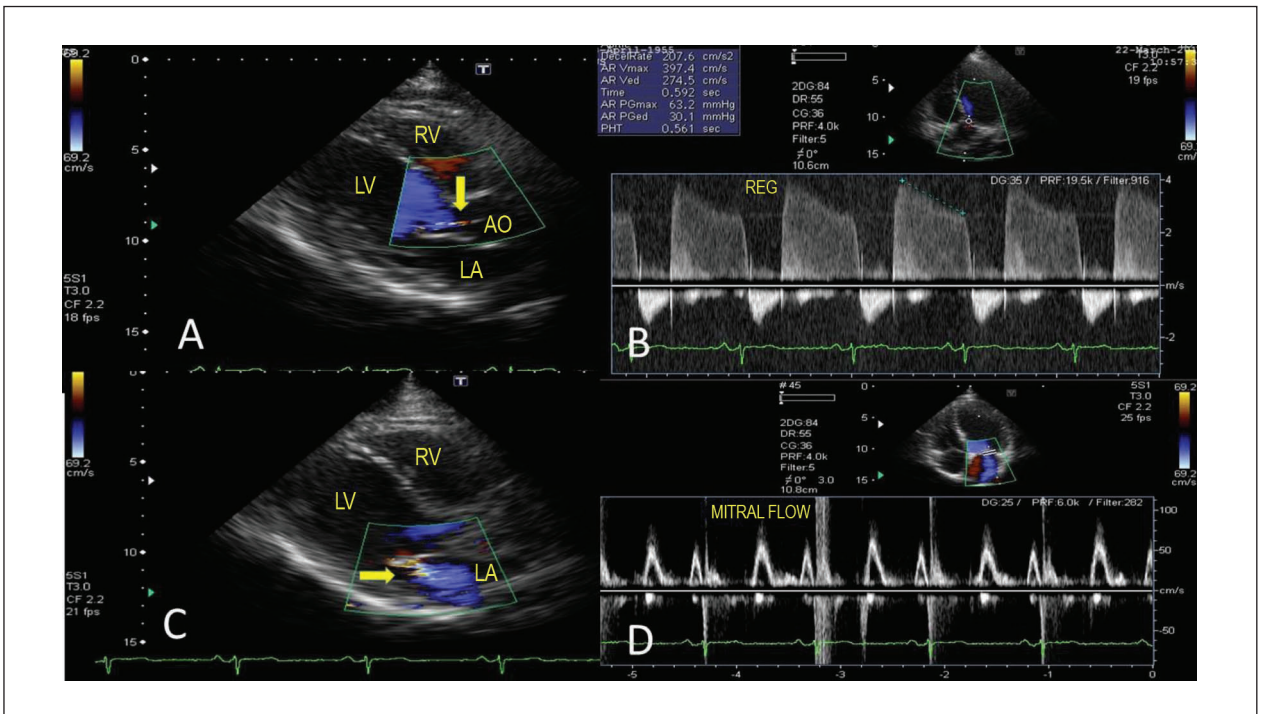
Echocardiogram after 2 years of dopaminergic medication. A and B - Longitudinal parasternal view and apical view showing mild aortic regurgitation on color flow mapping (yellow arrow) and continuous Doppler; C and D - color flow mapping and pulsed Doppler showing minimal mitral regurgitation (yellow arrow). RA: right atrium; LA: left atrium; AO: aorta; RV: right ventricle; LV: left ventricle.
